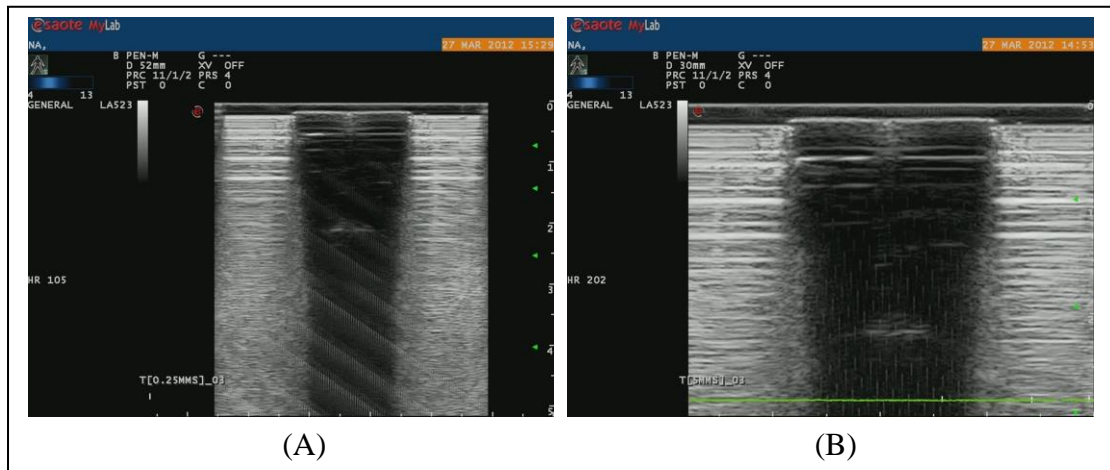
Ultrasound image recorded for different compression tests: (A) Ultrasound image recorded at lower frequency and higher beam penetration for compression test at 0.25mm/s; (B) Ultrasound image recorded at higher frequency and lower beam penetration for compression test at 5mm/s.
